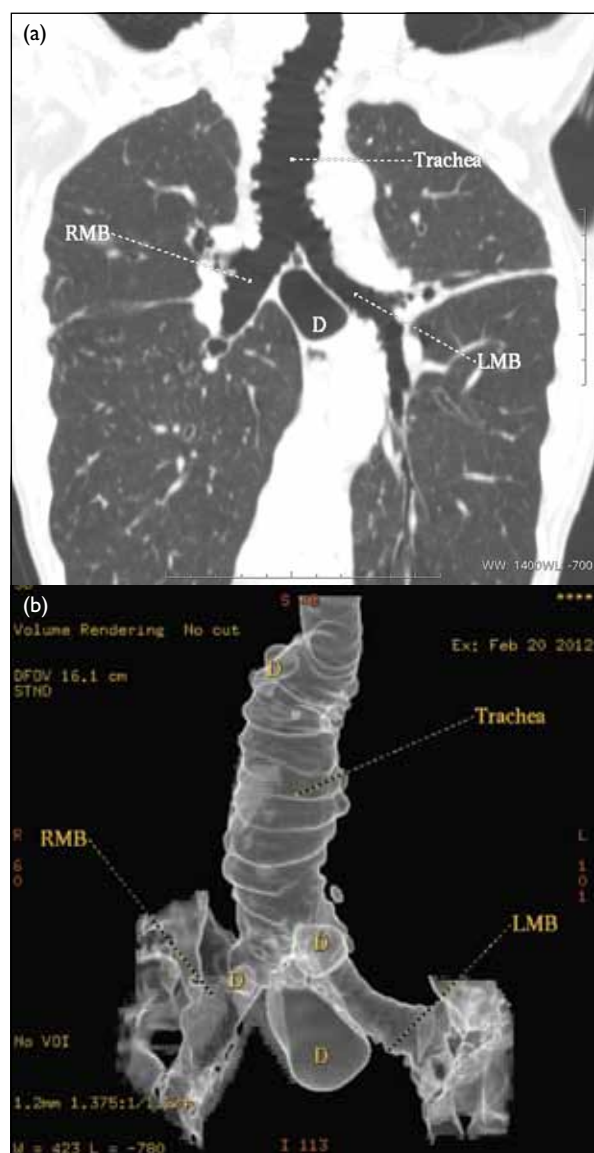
(a) Coronal reformatted computed tomography and (b) air surface 3-dimensional volume-rendering reformatted computed tomography of the thorax demonstrating an enlarged trachea, with bizarre eccentric configurations and a diverticulum. Bilaterally, the main bronchi are also ectatic. These findings are in keeping with type 2 Mounier-Kuhn syndrome. RMB denotes right main bronchus, LMB left main bronchus, and D diverticulum
